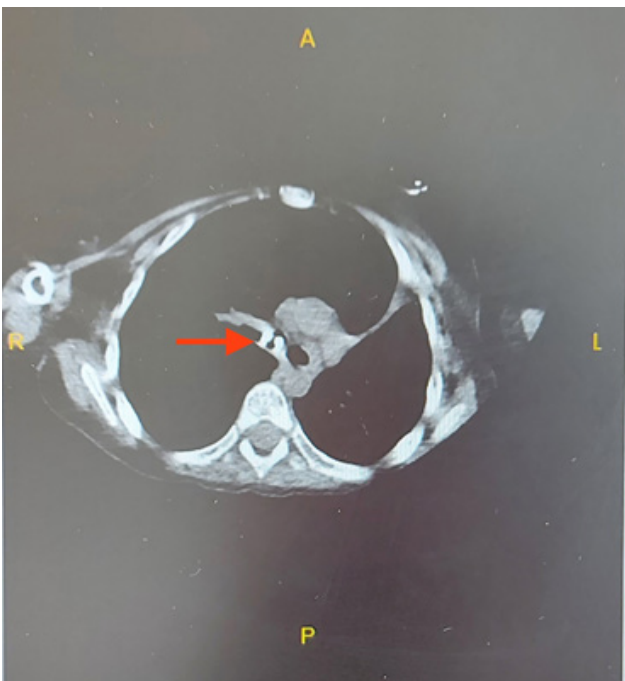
Foreign body image in the right main bronchus in computed tomography
